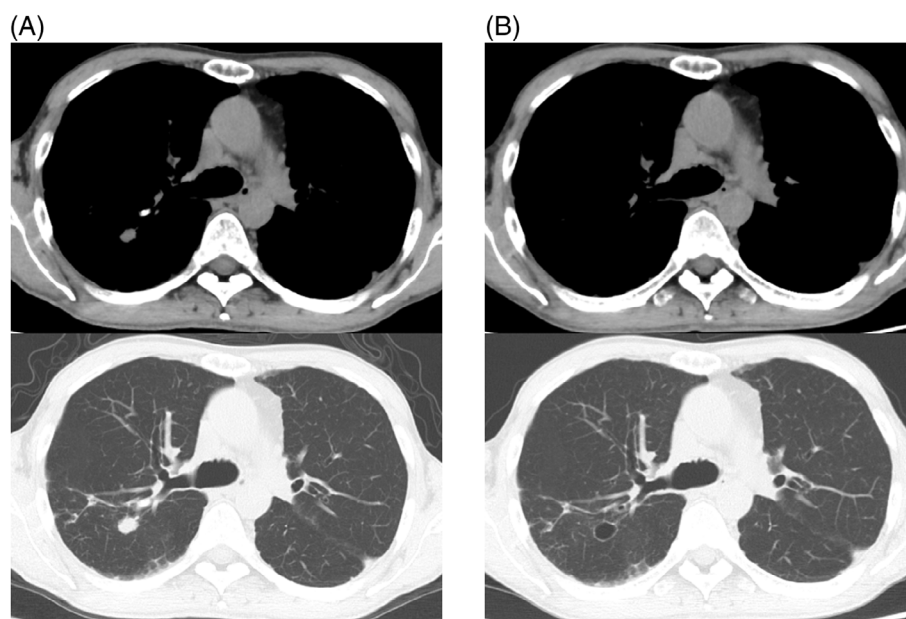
Chest computed tomography (CT) shows a lung nodule and a calcified lesion proximal to the nodule in the right upper lobe (A). After bronchoscopic removal of a broncholith, the lung nodule disappeared and a cyst remained on chest CT 1 month later (B).
